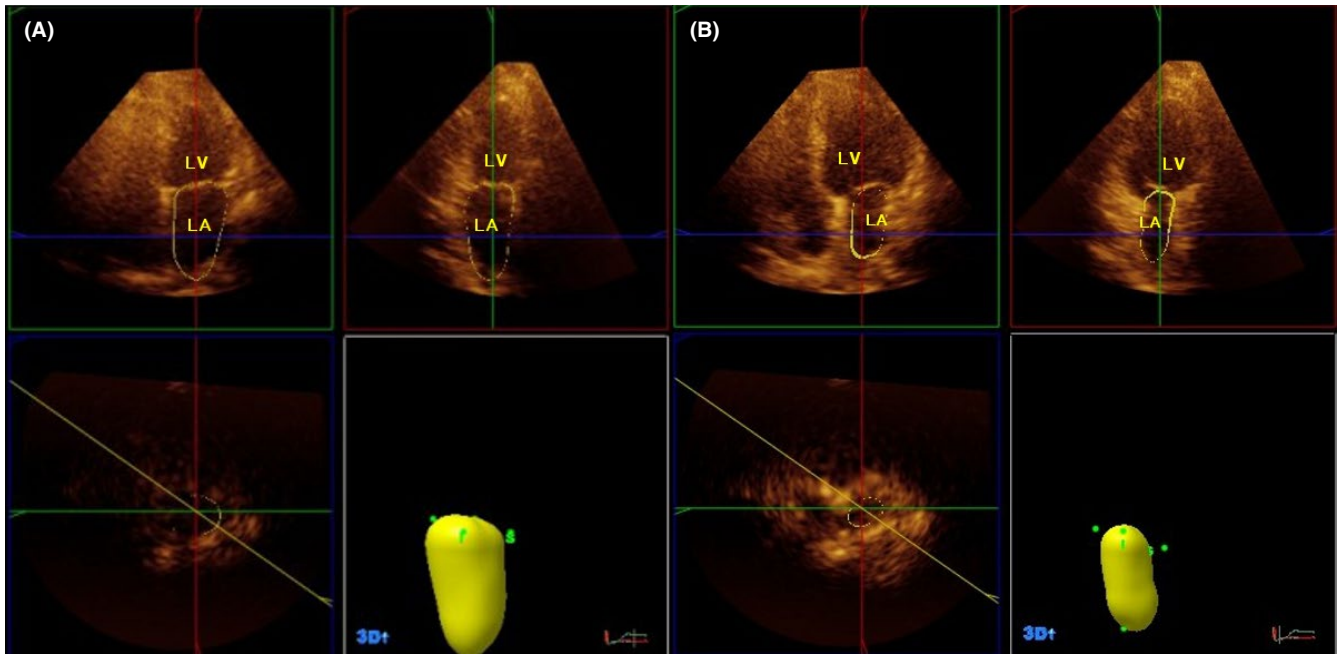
Real time three-dimensional echocardiography recordings of (A) maximal left atrial volume and (B) minimal left atrial volume. LA=left atrium; LV=left ventricle
